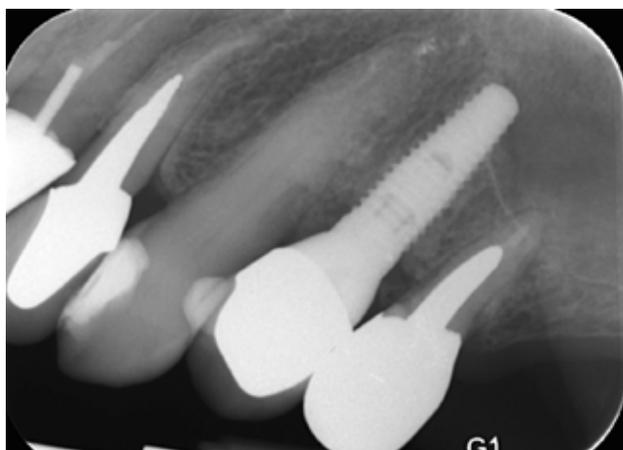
Radiographic appearance after 2 years showing evidence of regeneration and a stable radiographic appearance of the bone.
